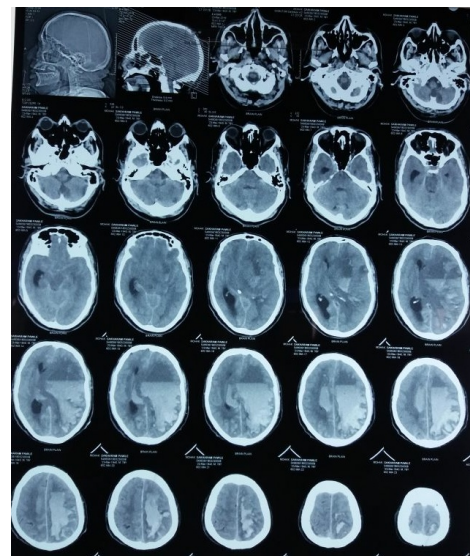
CT scan after tissue plasminogen activator (alteplase) showing massive intracranial hemorrhage in left fronto-parietal region.
